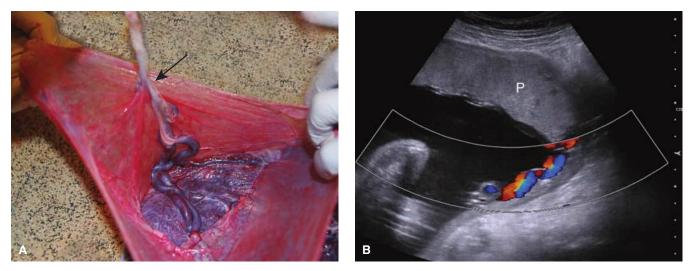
Velamentous cord insertion. A. The umbilical cord inserts into the membranes (*arrow*). From here, the cord vessels branch and are supported only by membrane until they reach the placental disc. B. When viewed sonographically and using color Doppler, the cord vessels appear to lie against the myometrium as they travel to insert into the margin of the placental disc. (*P*).
